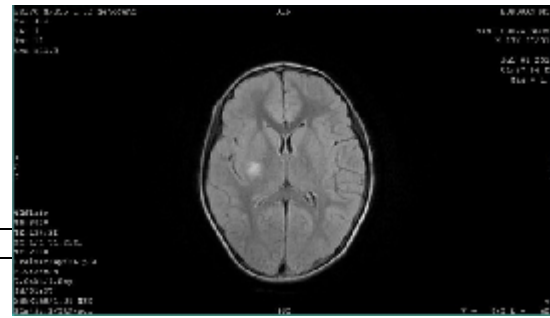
MRI Brain T2 FLAIR showing infarct in the right basal ganglia
